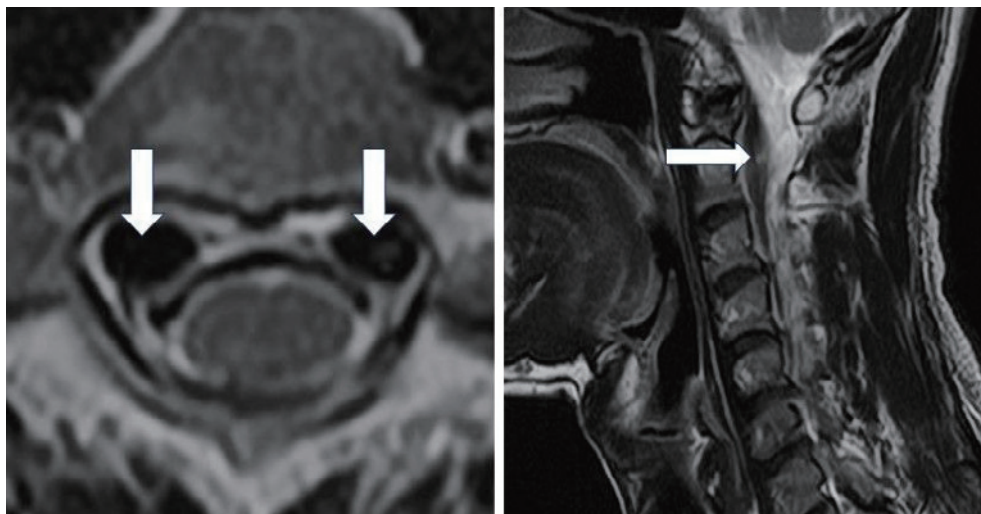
T2-weighted MRI shows significant dilatation of the anterolateral dural canal veins (white arrow) at the C2 level.
